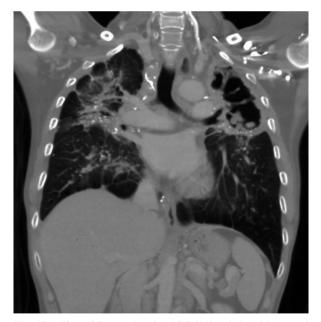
Chest CT scan showing LUL ball-in-hole with coronal section.
